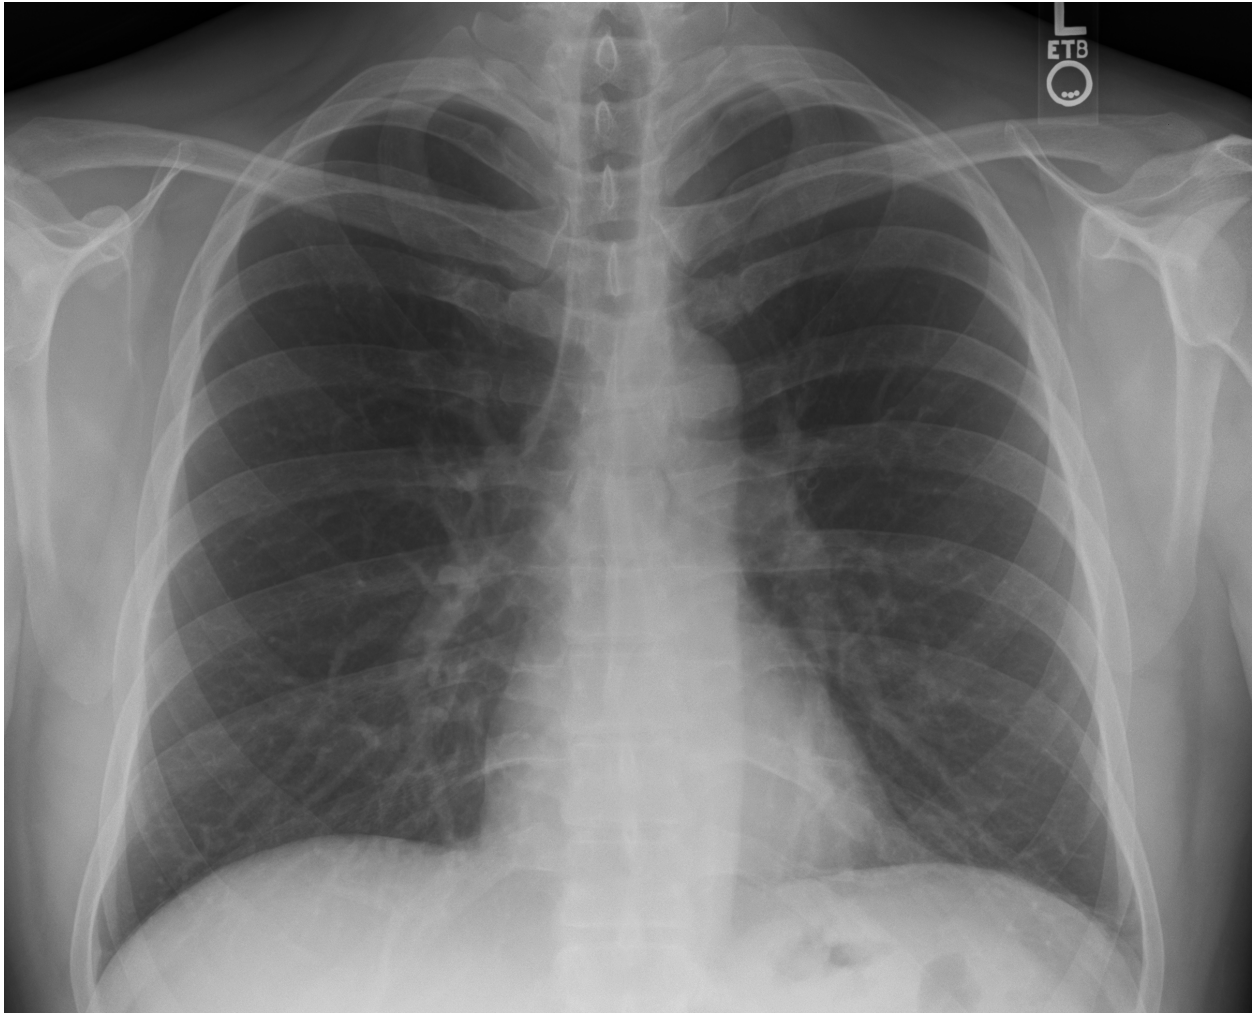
Image source: Stillwaterising. Normal PA chest radiograph. In: Wikimedia Commons. [https://commons.wikimedia.org/wiki/File:Chest\\_Xray\\_PA\\_3-8-2010.png](https://commons.wikimedia.org/wiki/File:Chest_Xray_PA_3-8-2010.png). Published March, 2008. Accessed March 10, 2020. Public domain.
